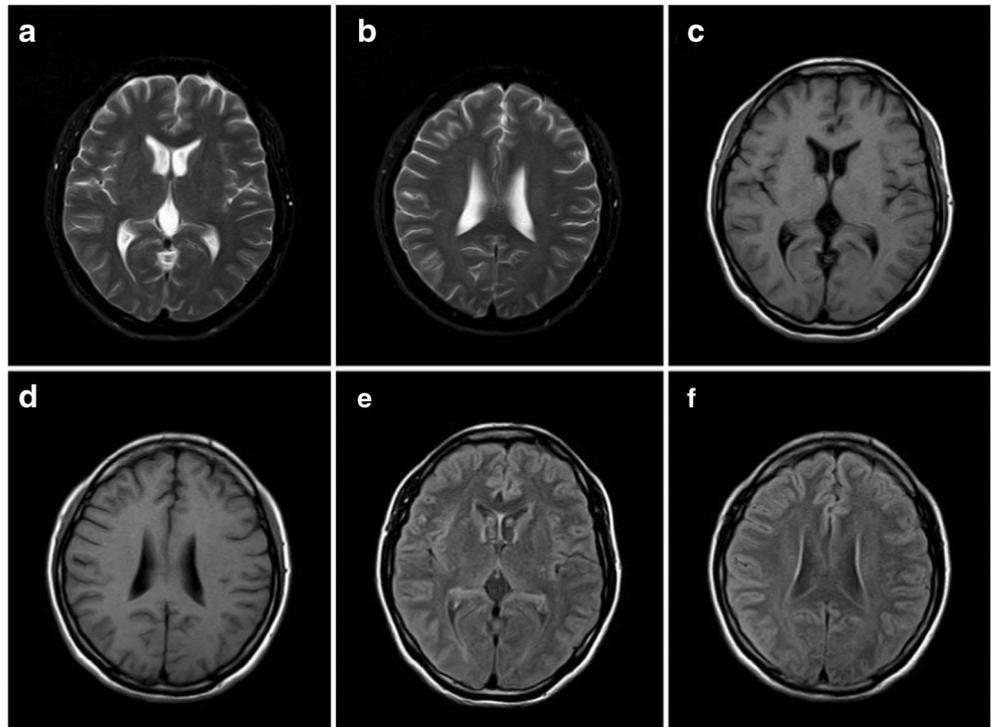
Brain MRI of the proband indicating bilateral periventricular demyelinating lesions of the cerebral white matter
